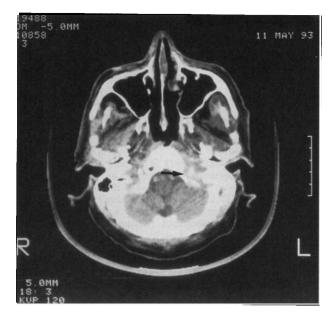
Case 1. Axial CT scan demonstrating erosion of the left jugular foramen, indicated by the arrow.
